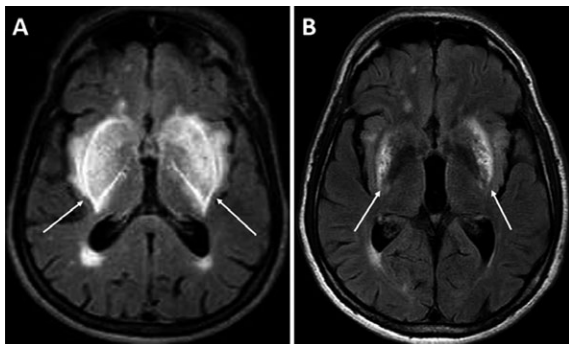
A: Axial FLAIR-weighted brain MRI shows bilateral symmetrical hyperintense signal in the basal ganglia surrounded by a more brightly hyperintense rim that delineates the lentiform nucleus. B: Axial FLAIR-weighted brain MRI performed 1 month after the beginning of symptoms shows a marked reduction in the hyperintense signal after treatment of myocardial infarction, cardiac failure, and hypotension.
